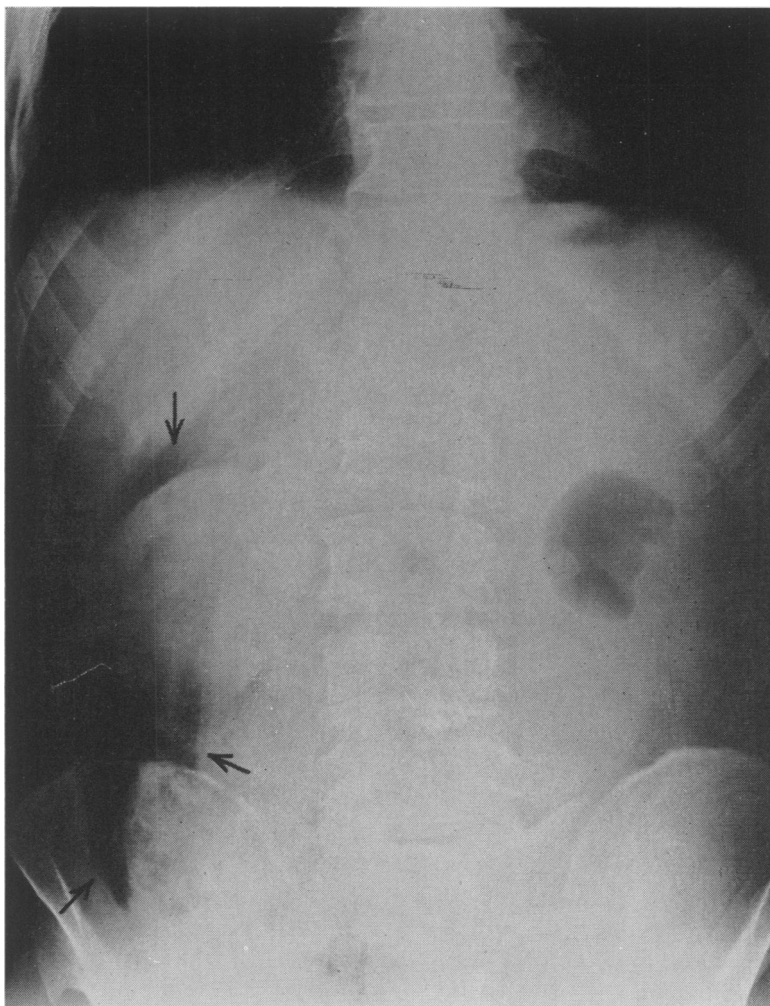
Upright roentgenogram of abdomen 10 hours after injury. The legend employed by Sperling and Rigler,¹⁸ with Figure 1 of their case report is applicable here. Gas collected about right kidney, right psoas muscle, and retrocecal region is shown (arrows). Note bubble-like character of shadows, characteristic of emphysema of tissues rather than free gas.
